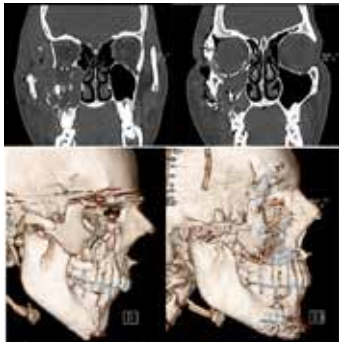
Pre- and Post-operative comparative CT scan.
